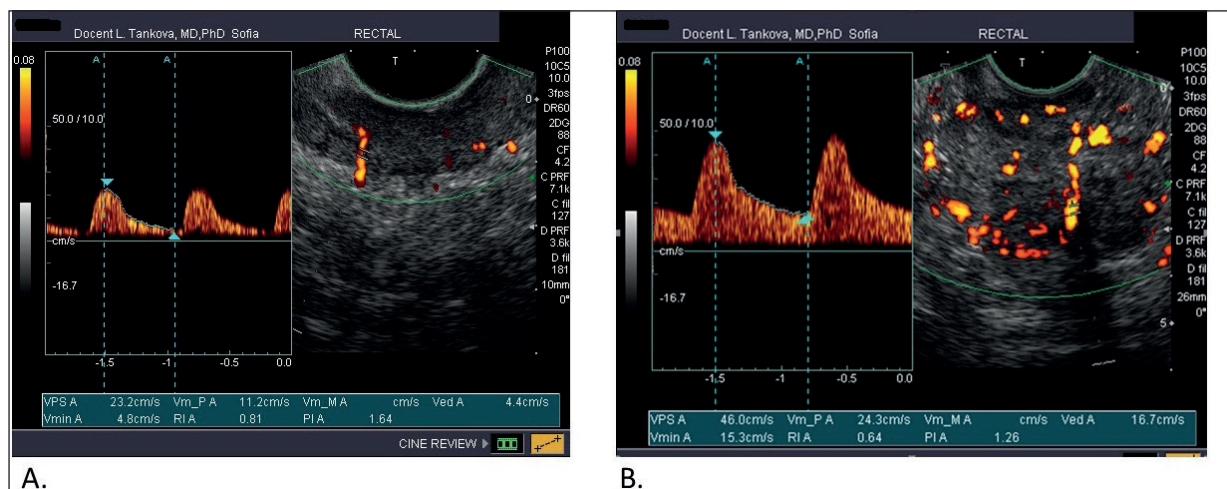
Power Doppler Endosonography of rectal cancer with poor vascularization (A) and high vascularization (B) – abundant chaotic vascularization in the center and periphery of the tumor.
